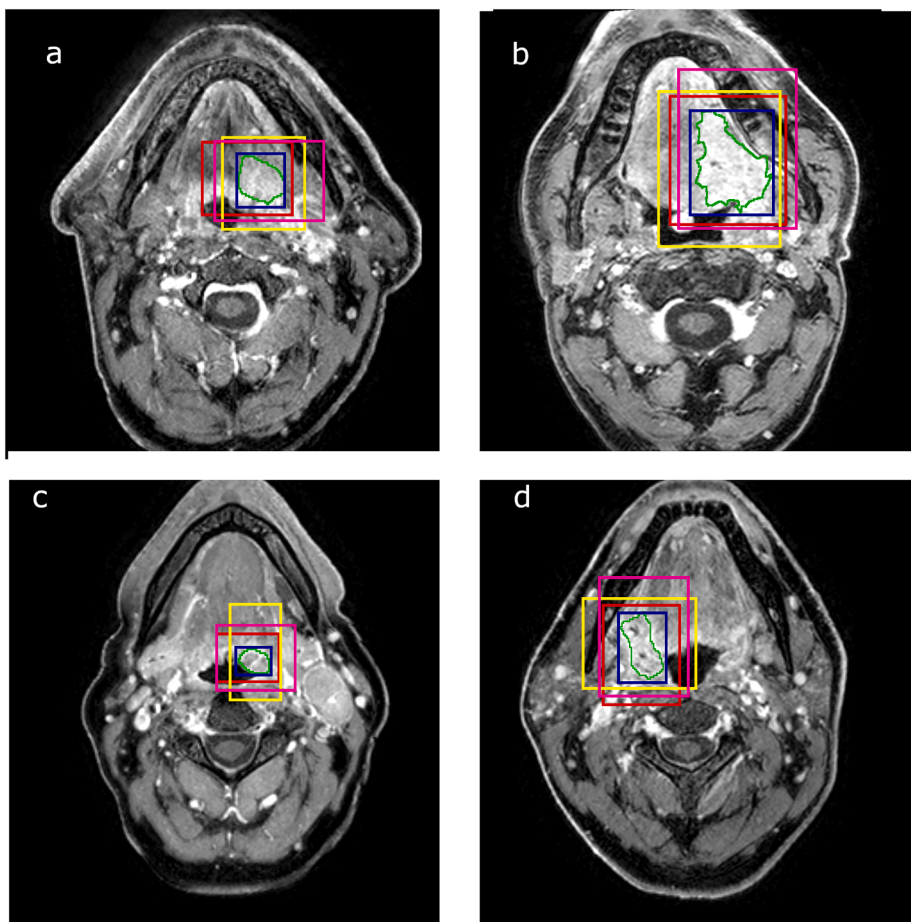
Original MRI image with the manual segmentation (green) of the oropharyngeal tumor. The blue boxes are the bounding boxes of the tumor. The rest of the boxes are used as inputs to the network during training. (For interpretation of the references to colour in this figure legend, the reader is referred to the web version of this article.)
